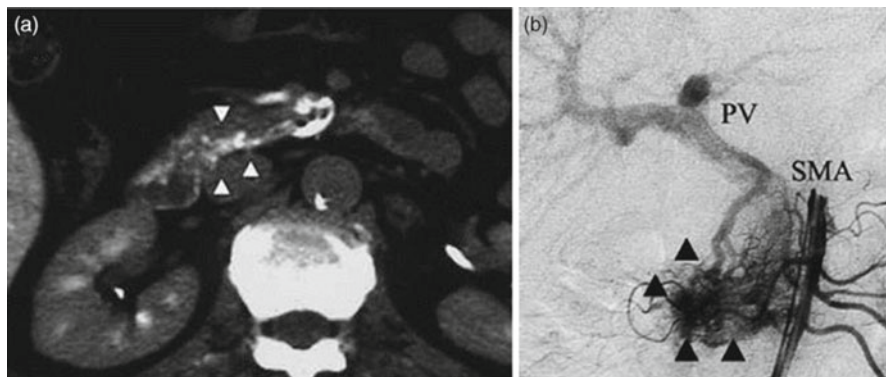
(a) Contrast-enhanced CT of a pancreatic arteriovenous malformation showing the hypervascular lesion. (b) Angiography of pancreatic arteriovenous malformation shows vascular proliferation and early filling of the portal vein in the arterial phase. From Uchida et al. [43]
